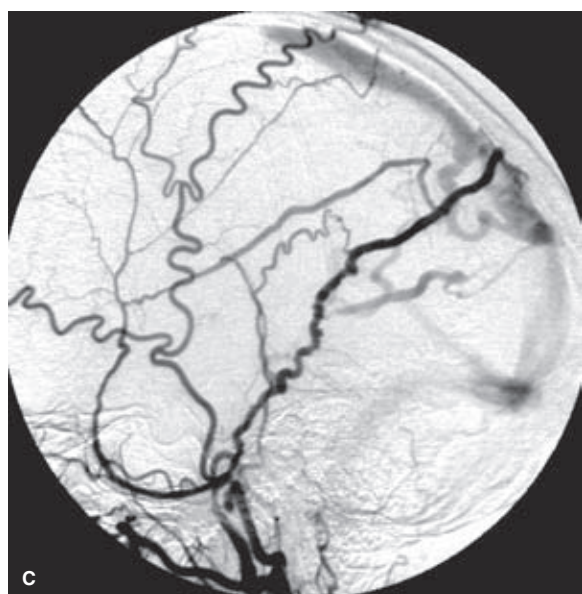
(A–C) “Collision” DAVM with underlying Glioblastoma Multiforme. A middle-aged patient presented with sudden onset of seizures and headaches. MRI demonstrated a right parieto-occipital parenchymal hematoma with mass effect, edema, and prominent surrounding flow voids (*arrowheads* in A, B). A diagnosis of a DAVM of the right parasagittal convexity was confirmed with angiography of the external carotid arteries (C). Transarterial embolization of the external carotid artery feeders was performed before surgical resection of the DAVM. Unfortunately, the parenchymal signs of complications from the DAVM masked signs that the patient had a coexistent glioblastoma multiforme in the same location. It is intriguing to wonder if the angiogenic factors discussed in Chapter 19 associated with the pathophysiology of GBM were responsible for inducing a secondary adjacent DAVM in this patient.
